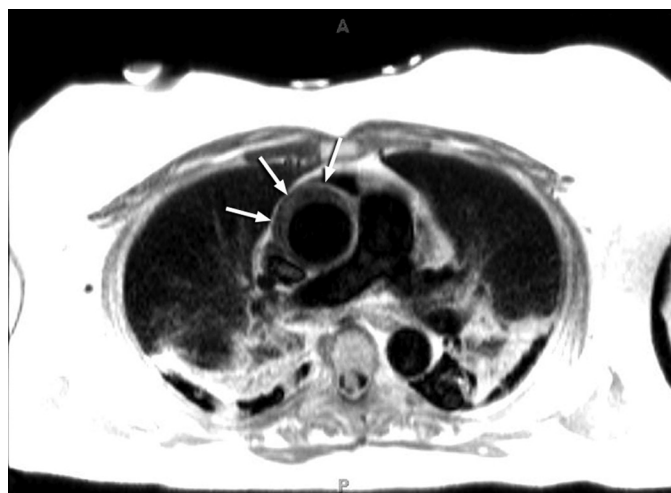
FIGURE e57-21 MRI of type A IMH of the aorta. The crescentic thickening of the aortic wall hematoma is denoted by *arrows*.
